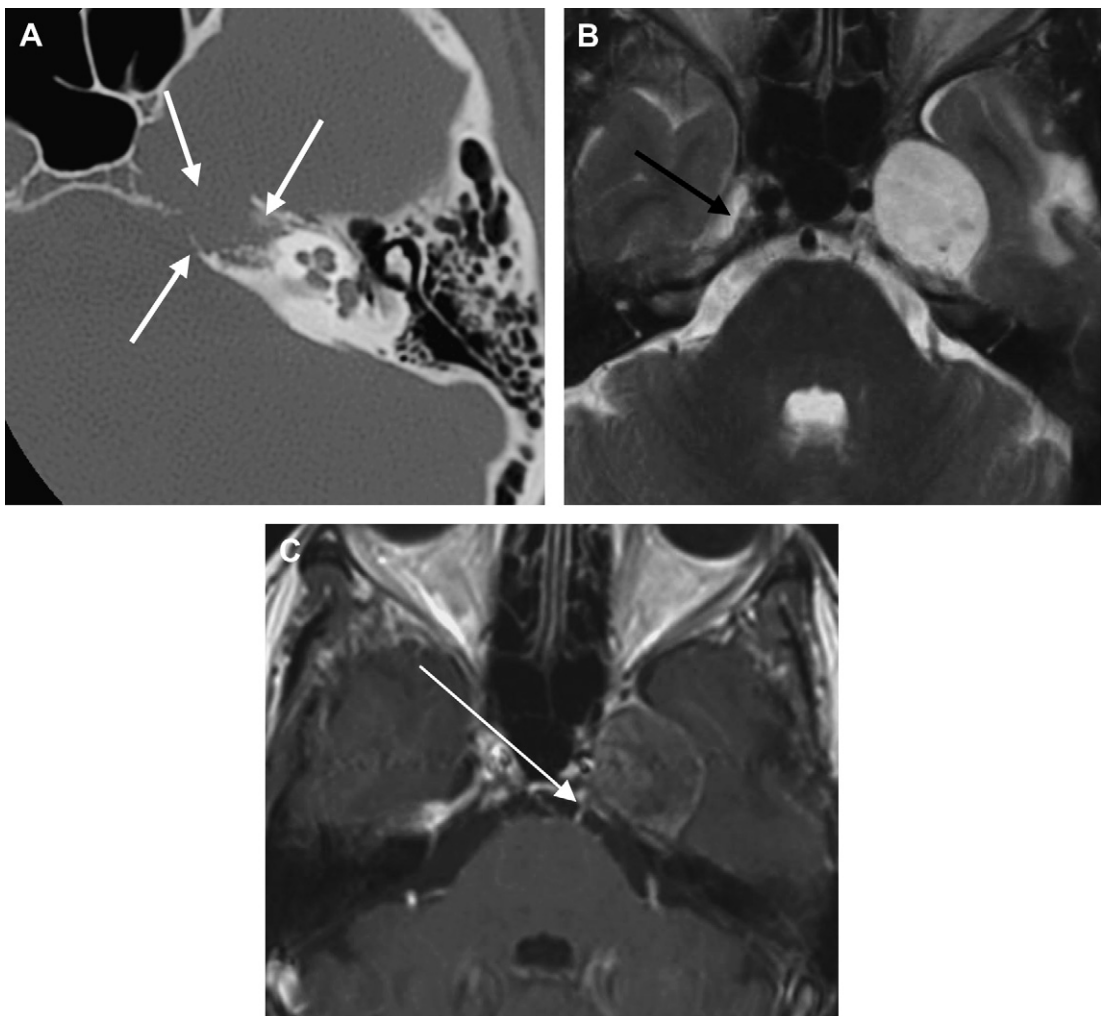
(A) Axial CT scan in a high-resolution bone algorithm shows a lytic destructive lesion on the left petroclival region (*white arrows*). (B) Axial T2-weighted and (C) postgadolinium axial T1-weighted images show an expansile lesion in the left petroclival region. The lesion is of high signal intensity on T2-weighted images, similar to CSF, and shows only slight to moderate enhancement after administration of gadolinium. It involves cranial nerve IV (*white arrow in C*) at Dorello's canal and obliterates Meckel's cave (note the normal cave on the contralateral side; *black arrow in B*). No gross calcifications are noted within the lesion (petroclival chondrosarcoma).
